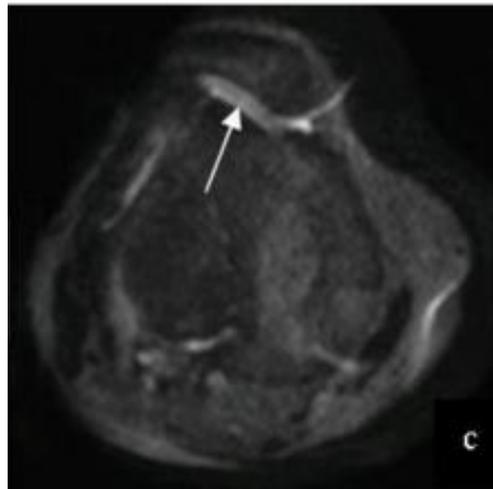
DWI (3.0 Tesla, TR/TE = 2000 msec/70 msec, Slice Thickness = 3mm) were expressed as a continuous cartilage and uniform signal (arrows) [2]
